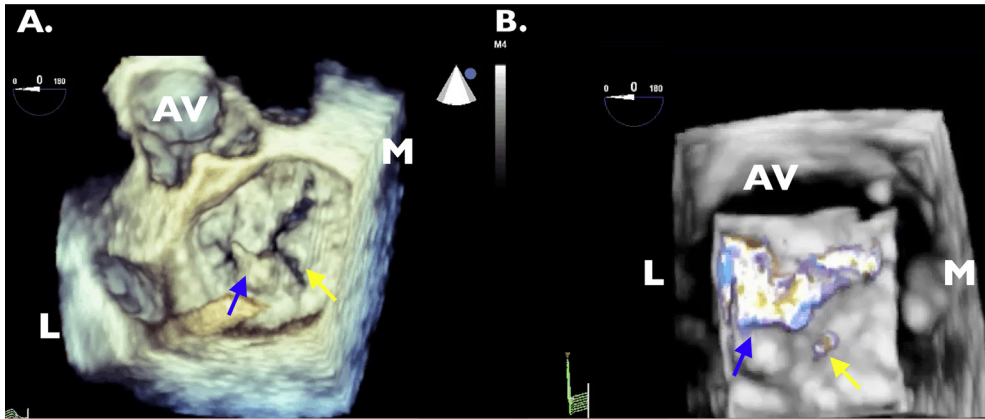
The 3D en face views of the MV from the LA perspective. (A) 3D Gated en face view of the MV demonstrating a P1 flail (blue arrow) and a central P2 cleft (yellow arrow). (B) 3D gated color flow Doppler of the MV demonstrating the dominant jet originating from the flail segment (blue arrow) and a trivial jet from the central P2 cleft (yellow arrow). AV, Aortic valve; L, lateral; M, medial. (See associated Video 2, available at www.onlinejase.com.)
